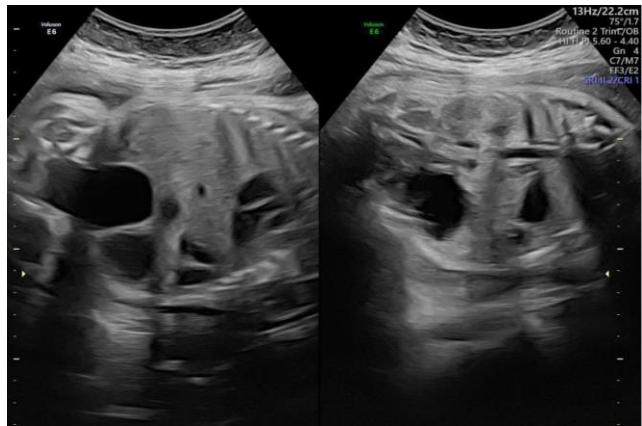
Ultrasound image showing a complicated fetal ovarian cyst
